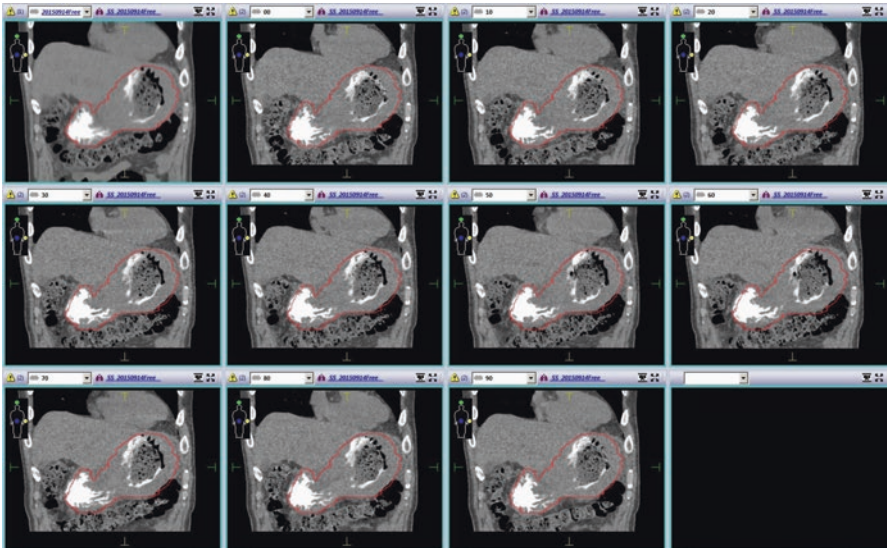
Intrafractional gastric motion on 4D CT images. Note that CTV on free breathing (red contouring) fail to include oral contrast media in some breathing phases
